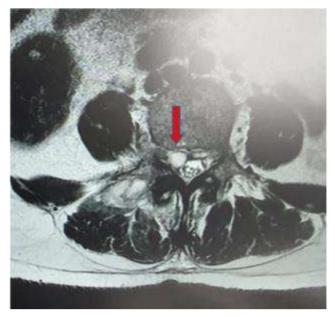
MRI axial view showing the epidural abscess (red arrow)
